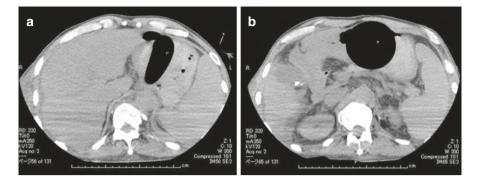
Inadequate use of an S-B tube. Computed tomography revealed that the balloons had slipped into the stomach because of inadequate traction and fixation of the balloon tube. (a) The esophageal balloon is within the stomach. (b) The gastric balloon is far from esophagogastric junction
